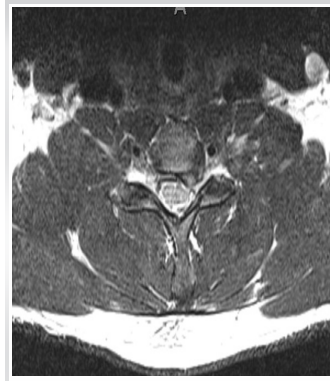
Pre-operative: Cervical spine MRI (Axial view).
